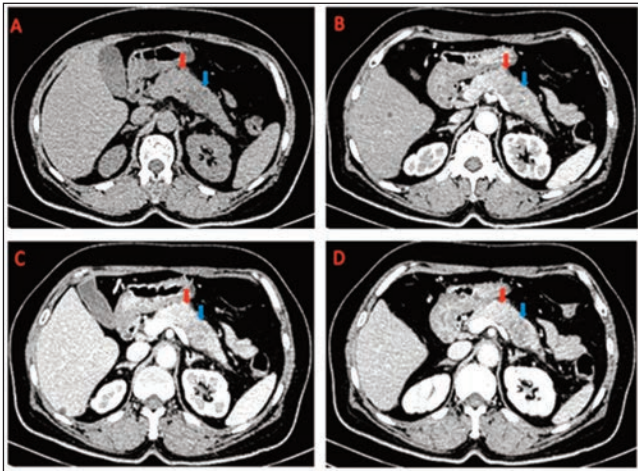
(A) Computed tomography imaging of scan period; (B) arterial phase; (C) Portal phase; and (D) venous phase are shown. Tubercular shadows were detected in the pancreatic neck and body, measuring 2.3x2.1cm (red arrow) and 2.7x2.4cm (blue arrow), respectively. Multiple small sac-like low-density shadows with clear boundaries were also seen.
